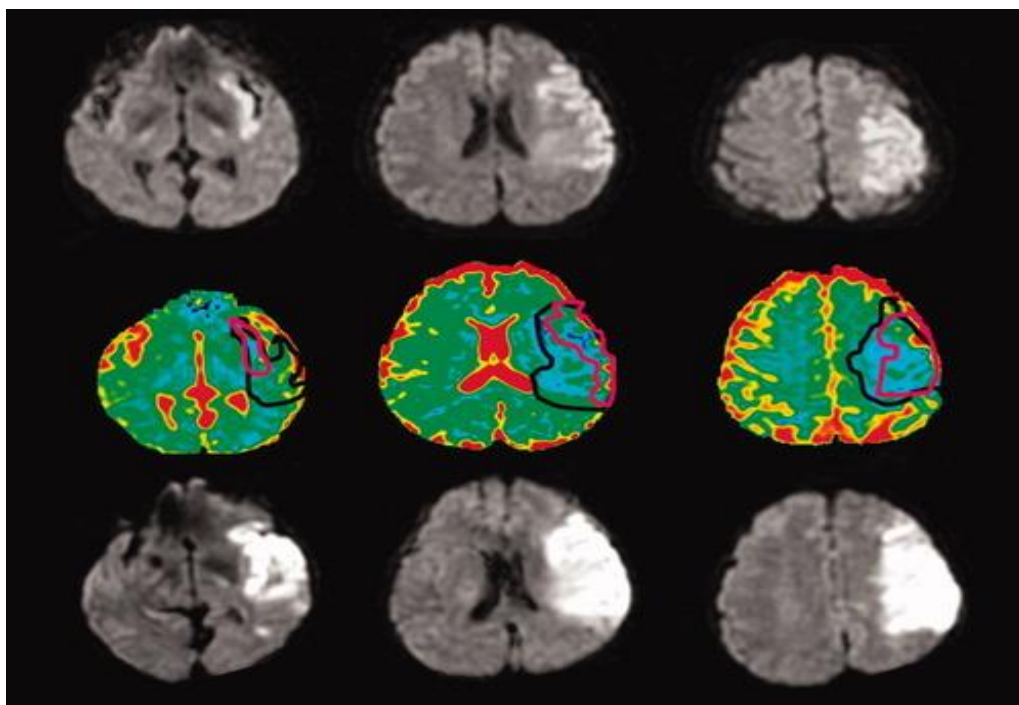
Using Diffusion MRI to estimate clinical ischemic penumbra. Top row, DWI obtained ~3 h after stroke onset. Middle row, pseudocolor images with outlines of initial DWI lesion (red line) and prediction of final infarct (black line) . Bottom row, follow-up DWI obtained ~24 h after stroke in this patient who was not recanalized (Images provided by Y. Samson.) (16).
